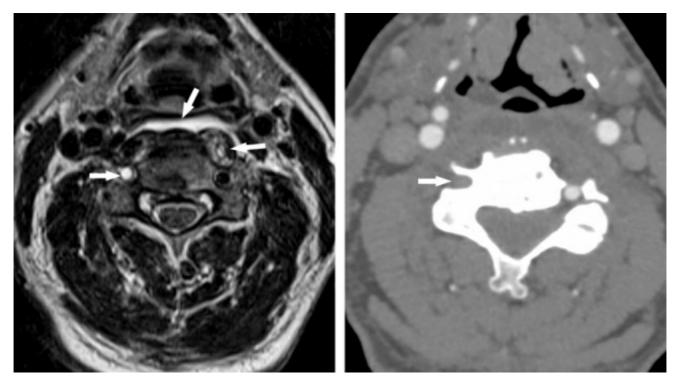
This patient receiving an MRI after motor vehicle accident demonstrates retropharyngeal and paraspinal muscle edema (left, middle arrow) on T2-weighted image (left), a finding suggestive of cervical spine fracture. More concerning, though, is the asymmetric abnormal signal in the right vertebral artery (left, left arrow), which should be black on T2-weighted images. On followup CT Angiogram (right), the right vertebral artery does not fill with contrast (right, arrow), indicating occlusion most commonly due to dissection in the traumatic setting.
